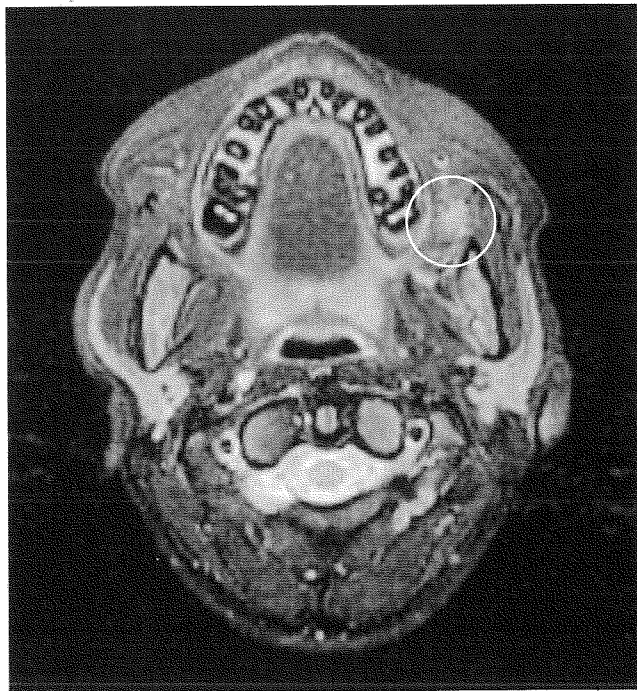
Axial MRI scan of case 7 showing a residual mass of rhabdomyosarcoma in the posterolateral maxillary region after intensive chemotherapy.
